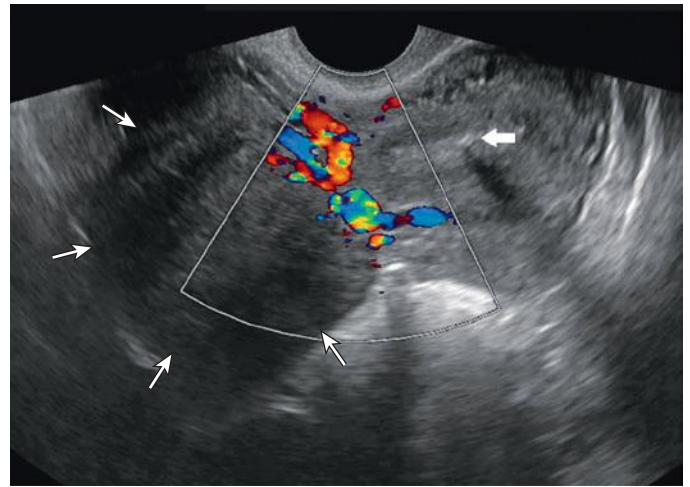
Pedunculated leiomyoma. Transaxial transvaginal color Doppler sonogram of the uterus demonstrating an echogenic focus (large arrow) with associated posterior shadowing within the endometrium, indicating an intrauterine device. Note right-sided hypoechoic solid mass (small arrows) in direct continuity with the myometrium, consistent with a large pedunculated subserosal leiomyoma. Note that color Doppler sonogram imaging can be used to show bridging myometrial vessels.
